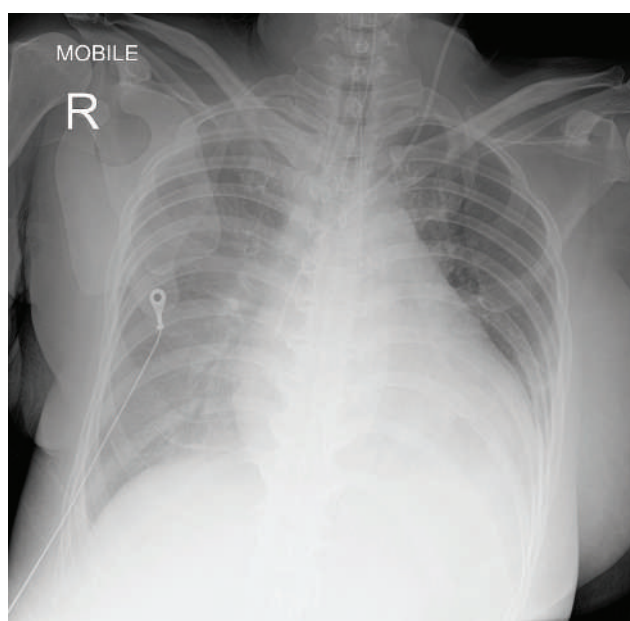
Chest radiograph showing cardiomegaly and pulmonary congestion upon admission.
